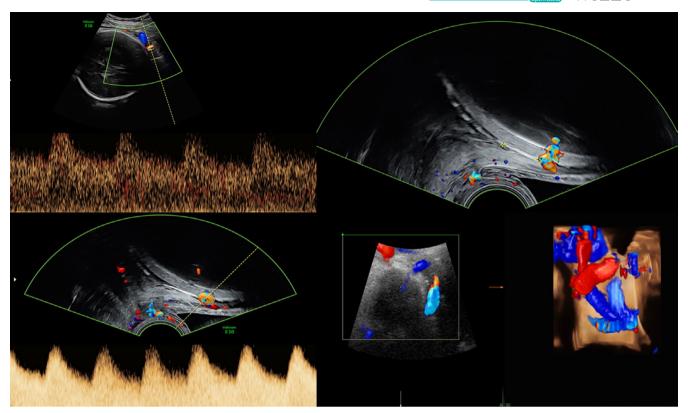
Case 4: Vessels with velamentous insertion overlying the cervix (transabdominal, transvaginal ultrasound with and without color-coded Doppler)—3D mapping of the vessels causing vasa previa
